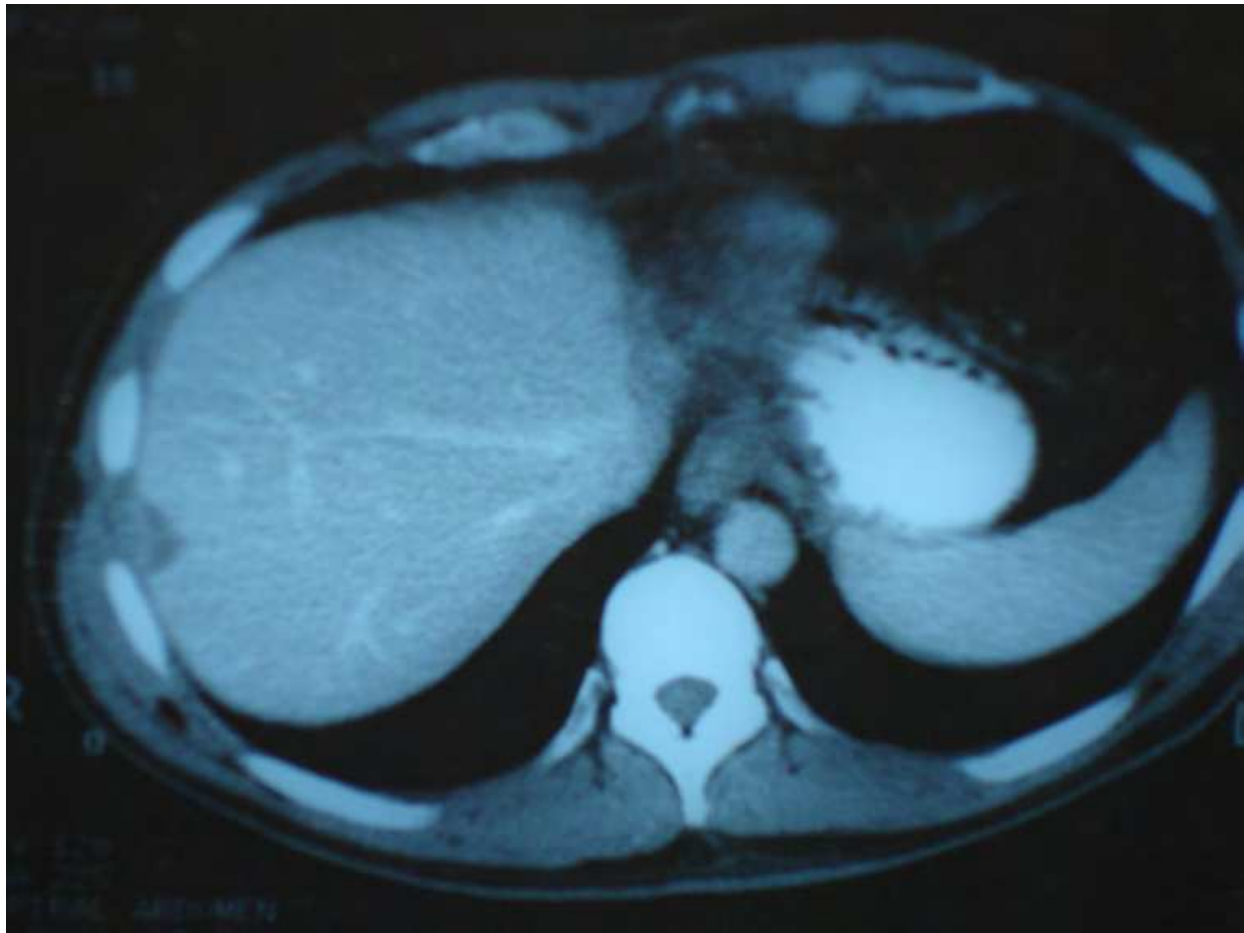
a, b, c: Example of a good response to chemotherapy leading to resection of the metastatic disease. (a) CT of a patient with a large left lobe liver metastatic lesion from CRC. (b) Decrease in size of metastatic lesion after a full course of chemotherapy. (c) CT scan after the patient underwent a left hepatectomy and a radiofrequency ablation of a lesion on the right.
